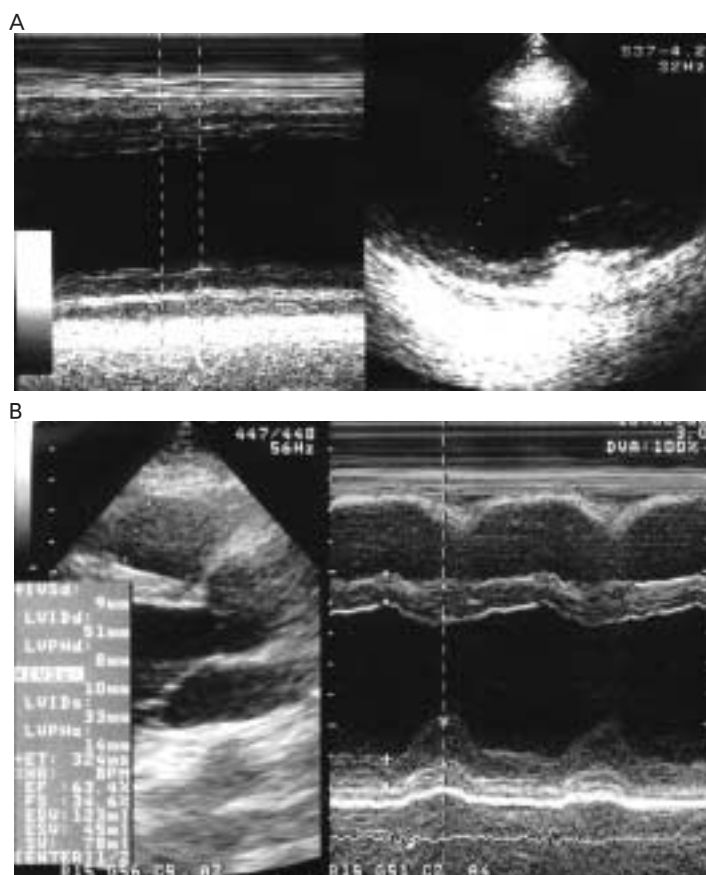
M-mode and two-dimensional echocardiograms pre-treatment (A) and post-treatment (B) are shown. The left ventricular wall motion recovered following percutaneous cardiopulmonary support.
